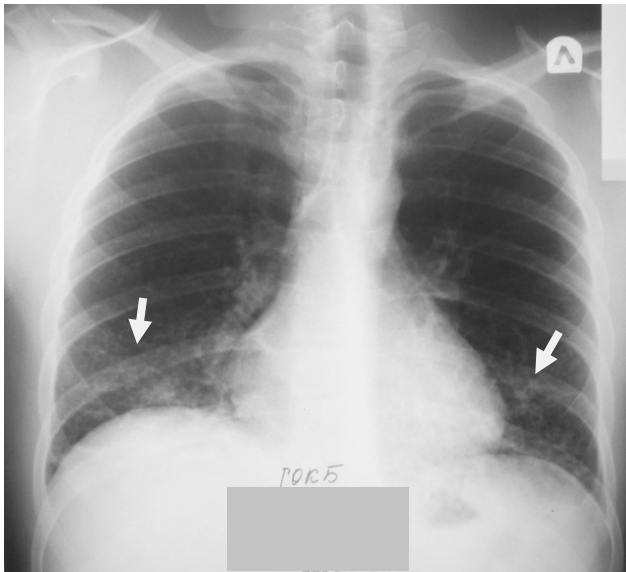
Chest radiograph. Frontal view. The highest number of nodular shadows (nodular patterns) is located in the inferior lung departments (arrows). Bronchopneumonia
